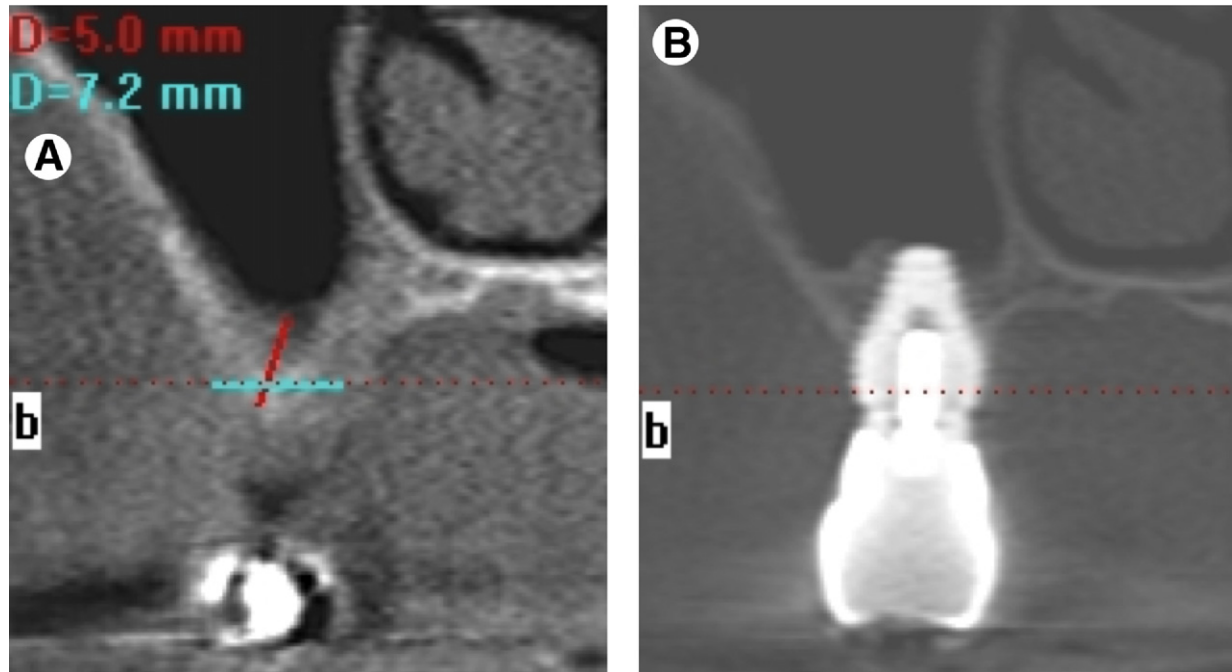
Cone beam computed tomography images preoperatively (A) and 1 year postoperatively (B) with restoration in place. The sinus lift elevation has stimulated apical bone apposition. On the other hand, buccal bone loss is visible because the original bone width was limited and the implant was obviously not completely surrounded by bone.
